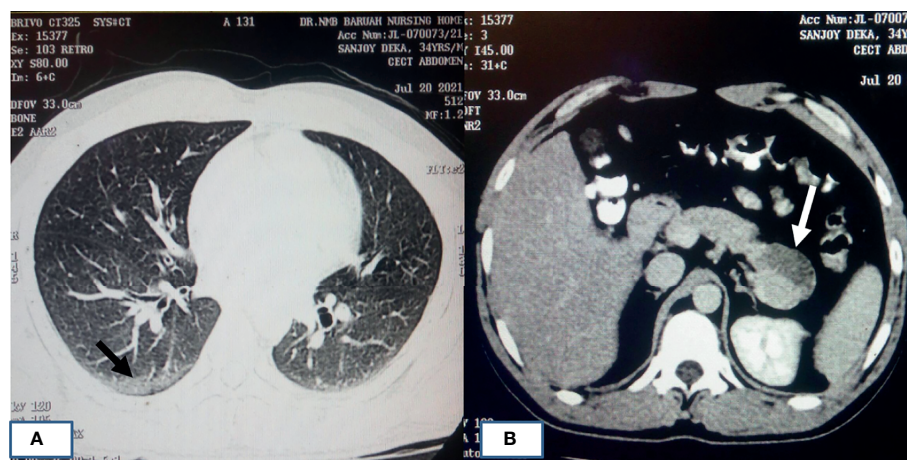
HRCT chest of patients with COVID-19 pneumonia and acute pancreatitis. (A) A 34-year-old male who had cough and painful abdomen showing typical imaging manifestations of COVID-19 pneumonia in the peripheral basal segment of right lower lobe (black arrow). (B) CECT abdomen image of same patient showing hypodensity in the tail of pancreas (white arrow) suggestive of acute necrotizing pancreatitis.
